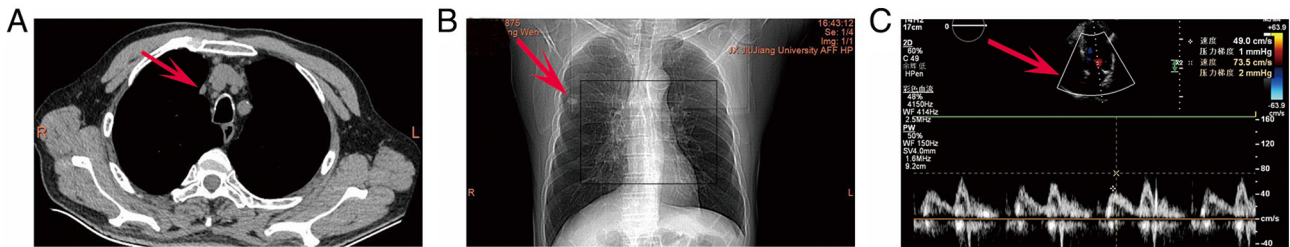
Clinical examination results. (A) A plain CT showing low-density shadows in both kidneys (red arrow). (B) Plain chest X-ray showing ground-glass nodules in the lungs (red arrow). (C) Heart color ultrasound (echocardiogram) revealing the condition of the heart.
